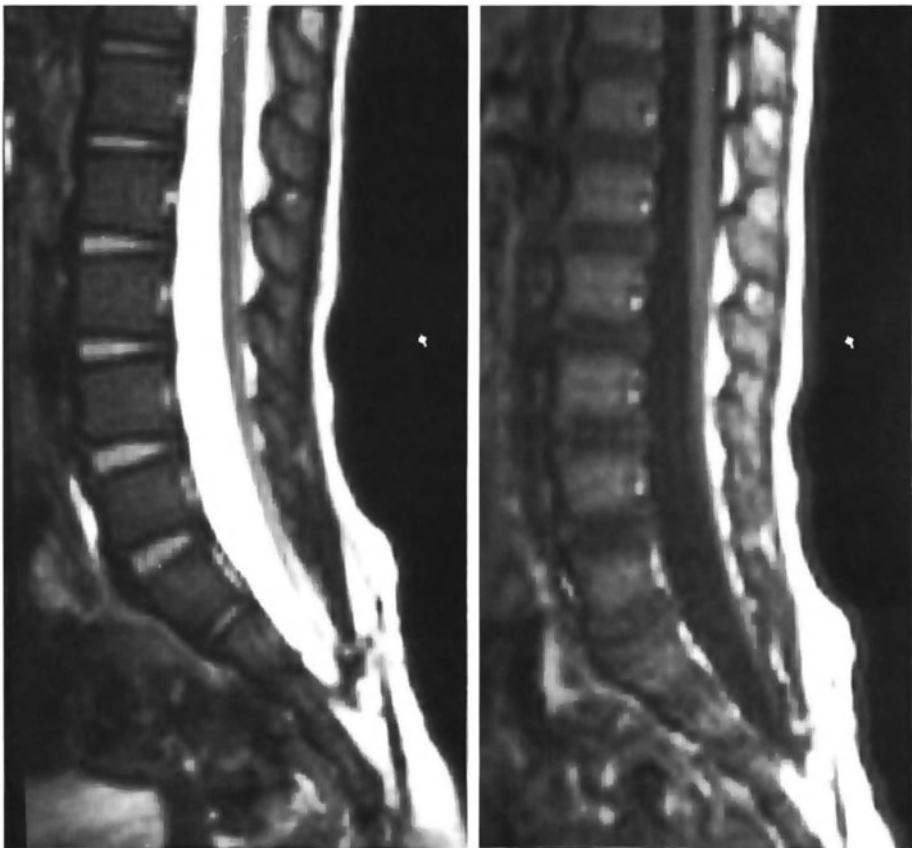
Thick filum terminale. MRI aspects of tethered cord with a thick filum. T1 and T2 weighted images
